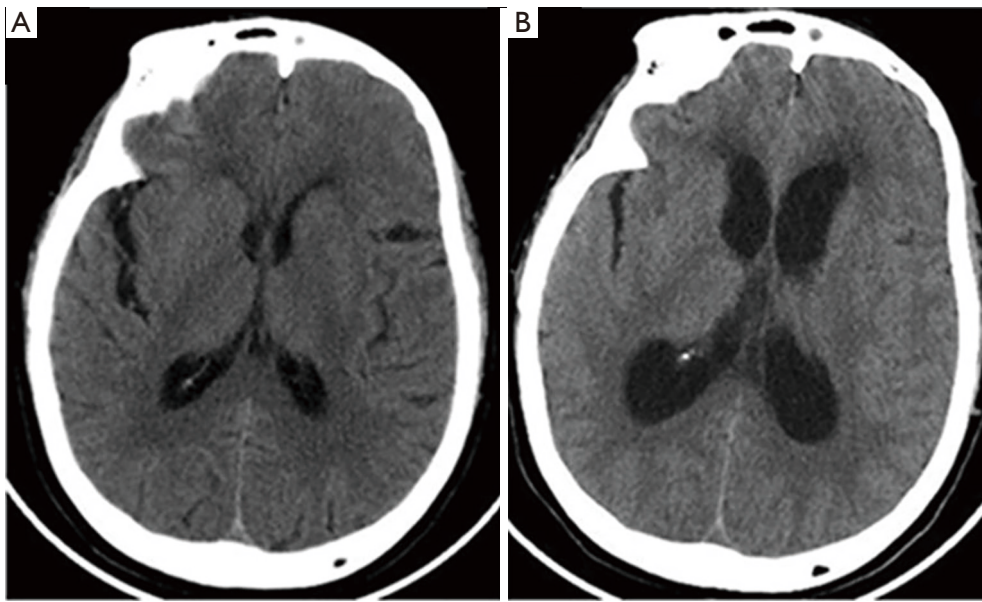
Time-dependent CT observations. (A) CT scan performed three days after the onset of illness revealed no obvious abnormalities; (B) CT scan obtained on admission showed bilateral hydrocephalus. CT, computed tomography.
